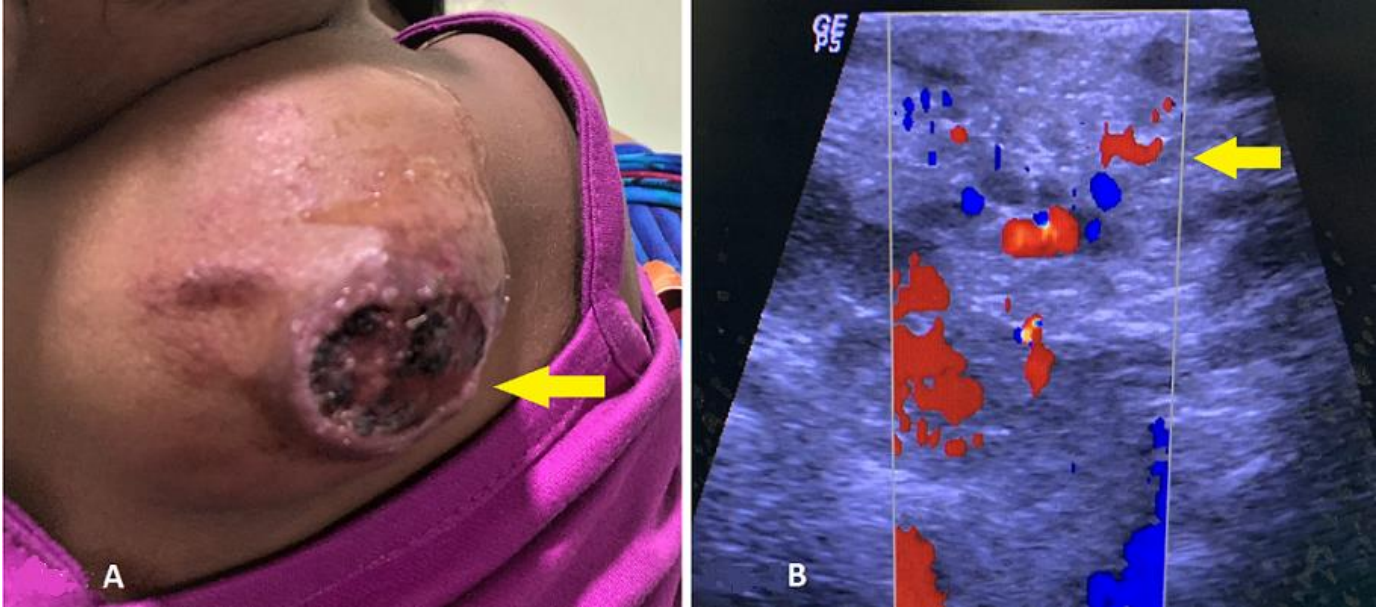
A) clinical image of the upper back of the child showing a large reddish mass lesion with ulceration (arrow); B) ultrasound image showing multiple anechoic cystic areas with Doppler showing increased vascularity (arrow) - arteriovenous malformation
